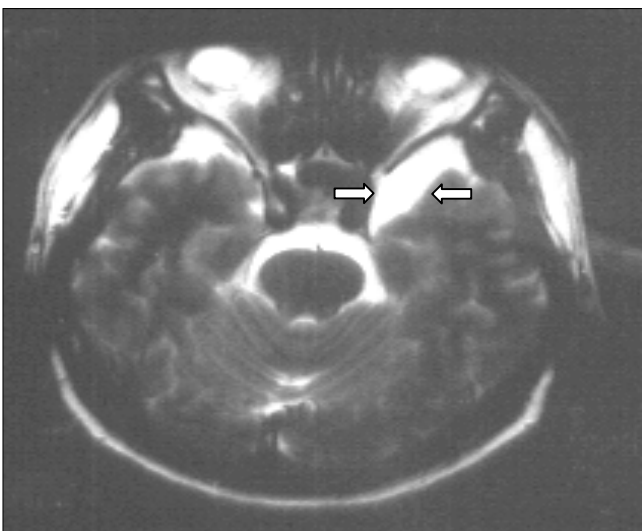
T2-weighted image of MRI shows ovoid-cystic lesion in the middle cranial fossa.
